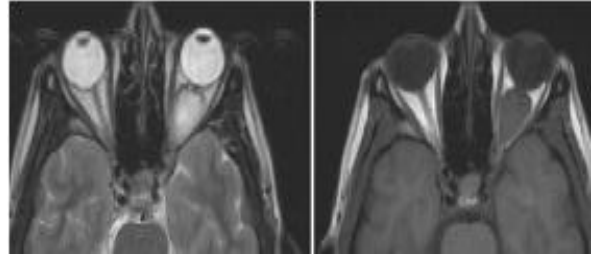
MRI of orbit (T2, T1 axial images) showing left optic nerve glioma.
